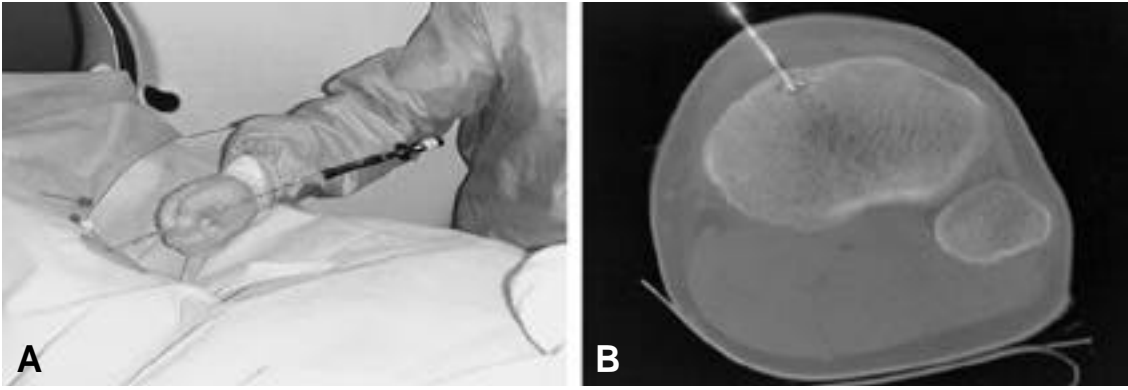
A. CT-guided needle bone biopsy was performed, and then, radiofrequency(RF) electrode was inserted at the lesion site.
